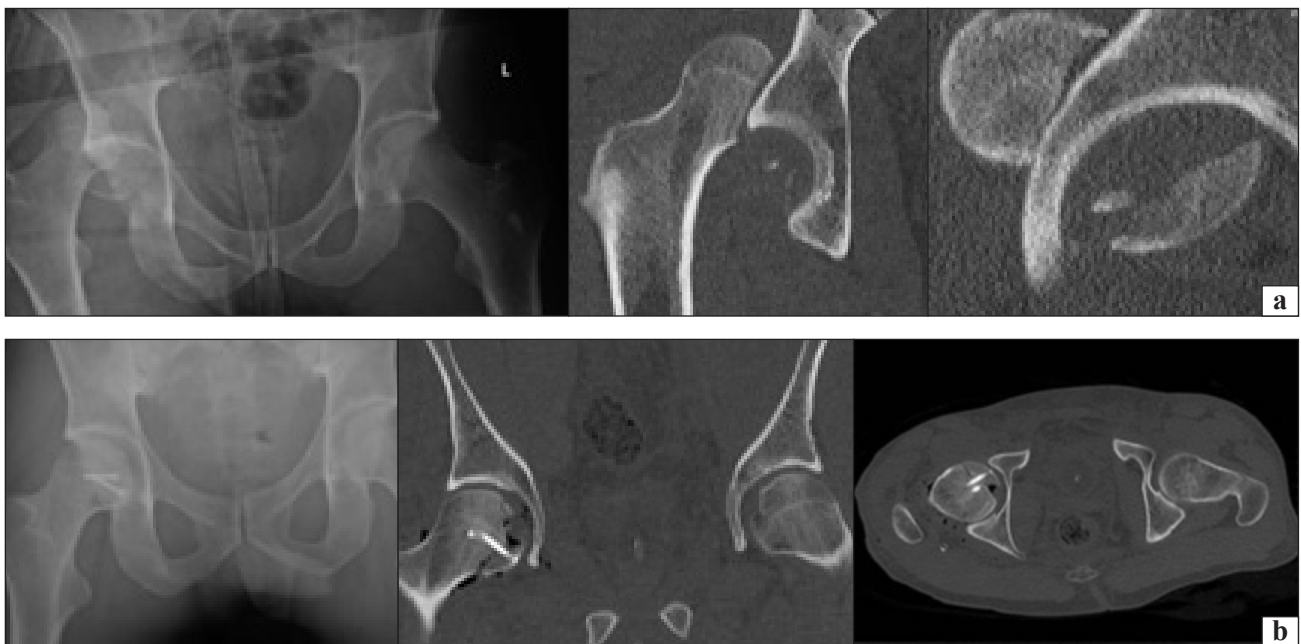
Photographs from X-rays of patient L. after injury (a) and after surgery (b)
